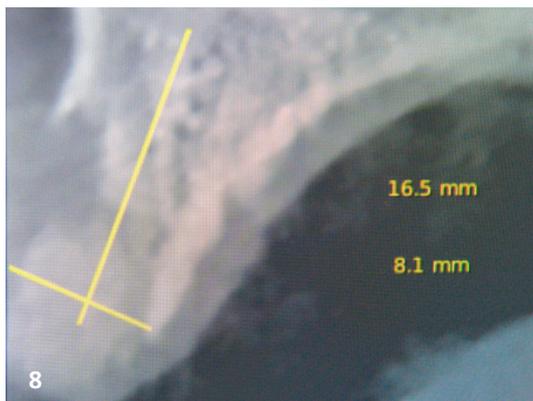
Diagnostics and planning using CBCT after three months follow-up. – Fig. 9: Bony situation at re-entry before the planned implantation. – Fig. 10: Drilling sequence for the planned ceramic implant (Neodent Zi).
